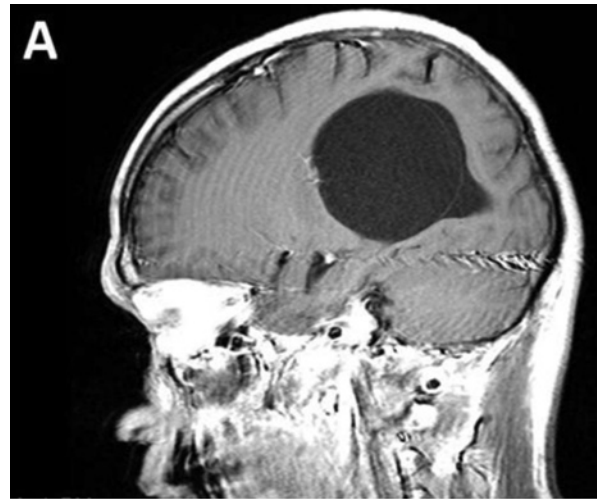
Magnetic resonance imaging of the brain with/without contrast (Panels A and B respectively) show a large solitary right ventricular cyst with partially calcified mural nodule. There is evidence of dysgenesis of the corpus callosum versus thinning of the posterior corpus callosum due to chronic mass effect.
